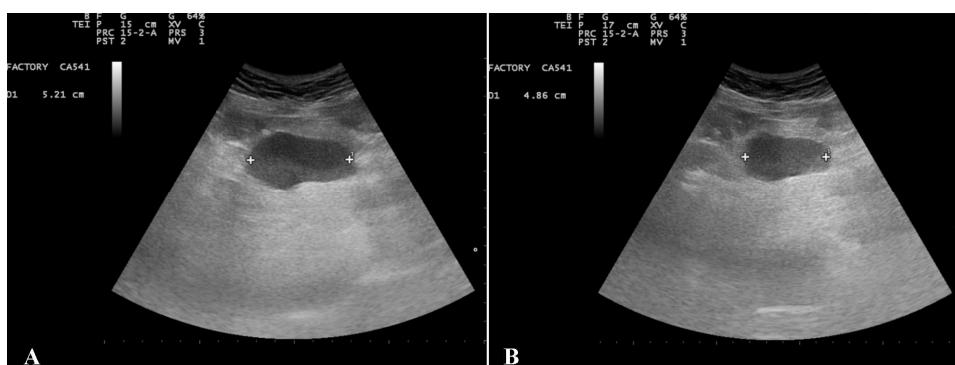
Ultrasonography of abdominal nodes. A 36-year-old man was diagnosed with metastatic melanoma. After 1 week of integrative immunotherapy where OA-GcMAF (880 ng/day) was administered by alternating nebulisation and intramuscular injections, one of the lesions in the abdomen, interpreted as coalescent metastatic peritoneal nodes, measured with ultrasonography, showed a decrease of its length from 52.1 mm (panel A) to 48.6 mm (panel B). This corresponds to an approximate 7% linear diameter reduction. In this case the volume could not be fully extrapolated since the mass showed an irregular elongated shape
